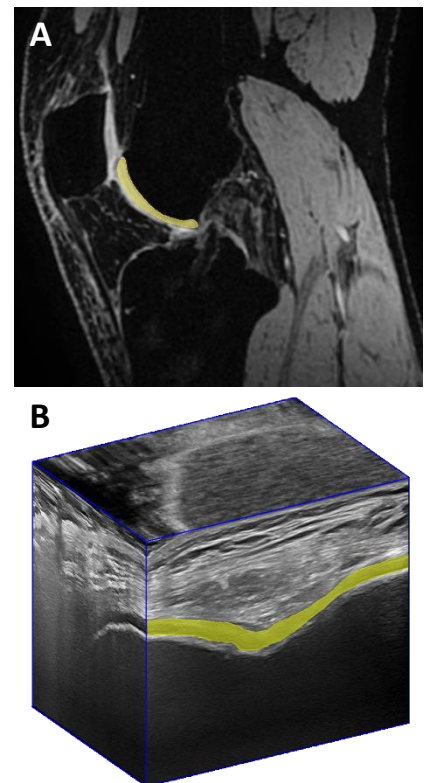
Manual segmentations of the trochlear FAC overlaid on MRI (A) and 3D US (B) images of a volunteer's healthy knee.
